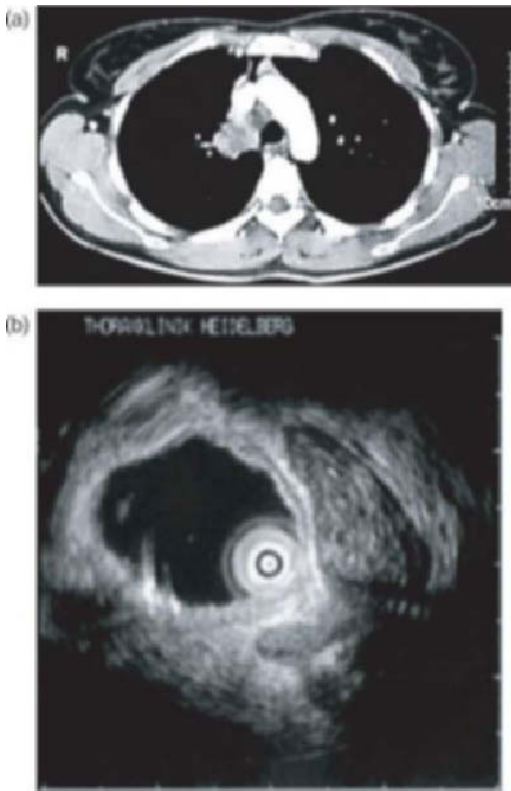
Example of a chest CT with central mass abutting the airway (a). This mass was classified as infiltrating the airway. (b) The corresponding EBUS exam demonstrating an intact outermost airway layer and as such no evidence of infiltration. The EBUS finding was confirmed at time of surgery.
